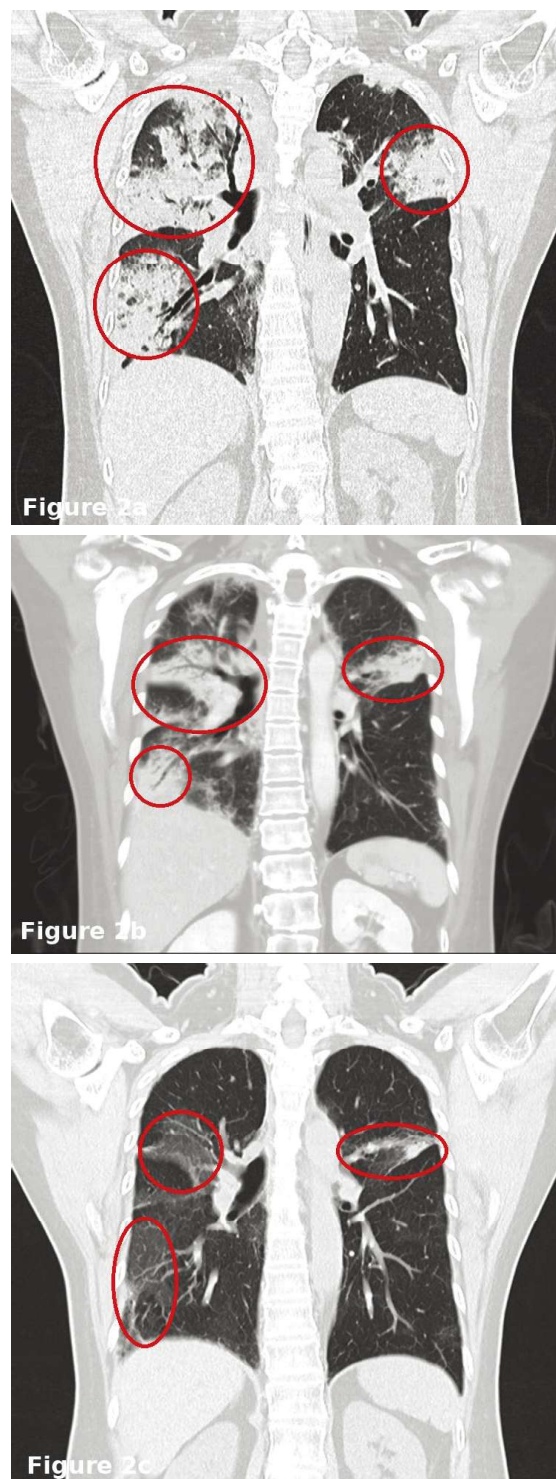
Serial chest CT imaging showing response to immunosuppressive therapy. 2a. HRCT on day 3 of admission showing multifocal patchy consolidation involving bilateral upper lobes, left lower lobe, and bilateral lower lobes. 2b. Chest/heart CT on day 19 of admission revealing persistent consolidation despite antibiotic treatment, raising suspicion of organizing pneumonia. 2c. Chest/heart CT 1 month after discharge showing significant radiologic improvement following steroid and immunosuppressive therapy.
